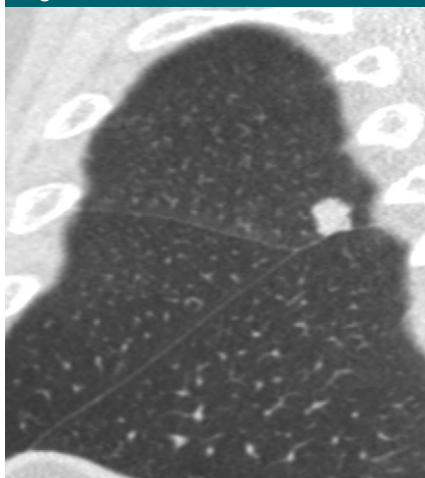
Sagittal CT image shows adenocarcinoma connected to a pulmonary fissure. Note the margins and that the nodule, unlike PFNs, is flattened at only one side.
